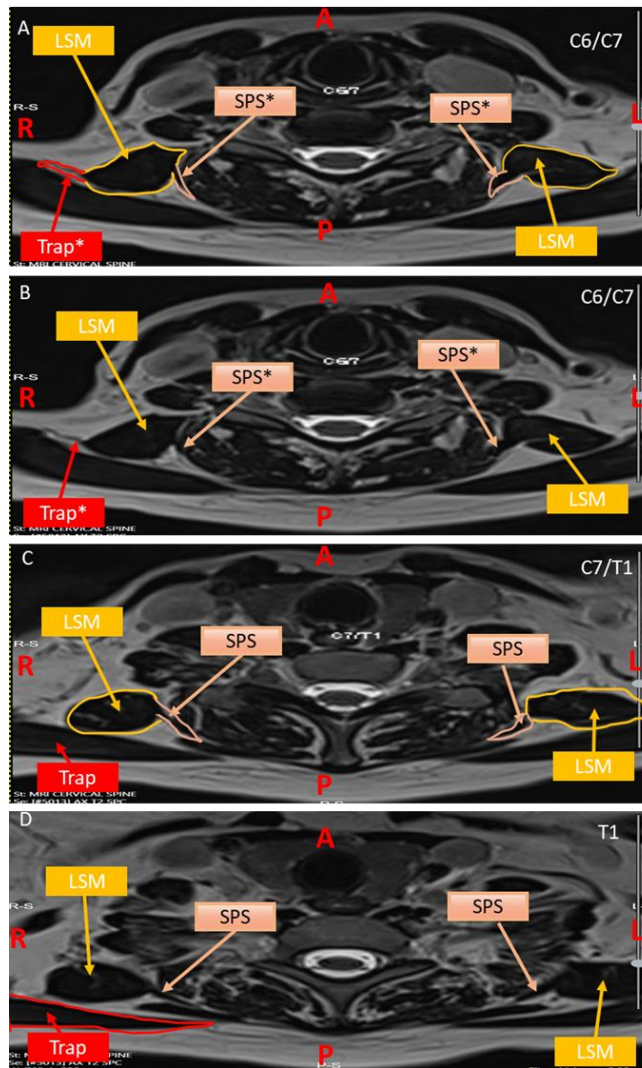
The axial cervical MRI scans with serratus posterior superior and trapezius attachments of levator scapulae muscle (A to D = superior to inferior). The MRI scans were obtained from a 52-year-old female patient (p# 4) with bilateral accessory attachments to the serratus posterior superior, and unilateral attachment to the trapezius muscle. Key: C- cervical vertebrae, LSM- levator scapulae muscle, Trap*- attachment to the trapezius muscle, Trap- trapezius muscle, SPS- serratus posterior superior, SPS*- attachment to the serratus posterior superior, T- thoracic vertebrae. Orientation in red: A- anterior, L- left, P- posterior, R- right.
